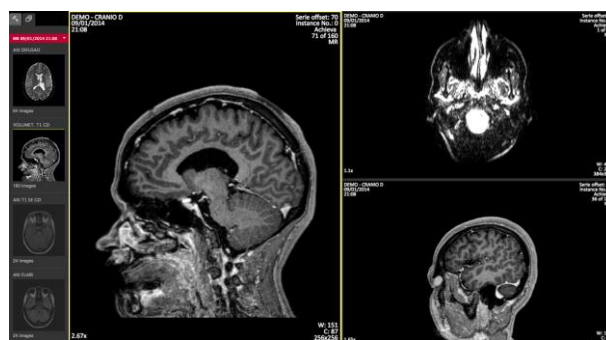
A DICOM MRI scan of a patient head.
